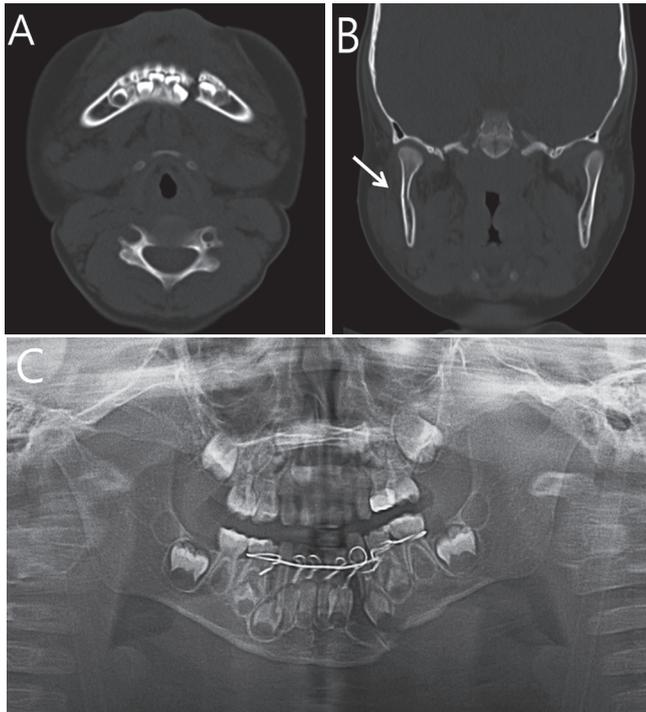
(A) Facial CT view after mandibular fracture. CT view showing fracture of left mandibular parasymphysis. (B) Green stick fracture of Right condyle. (C) Panoramic view after intermaxillary fixation.
